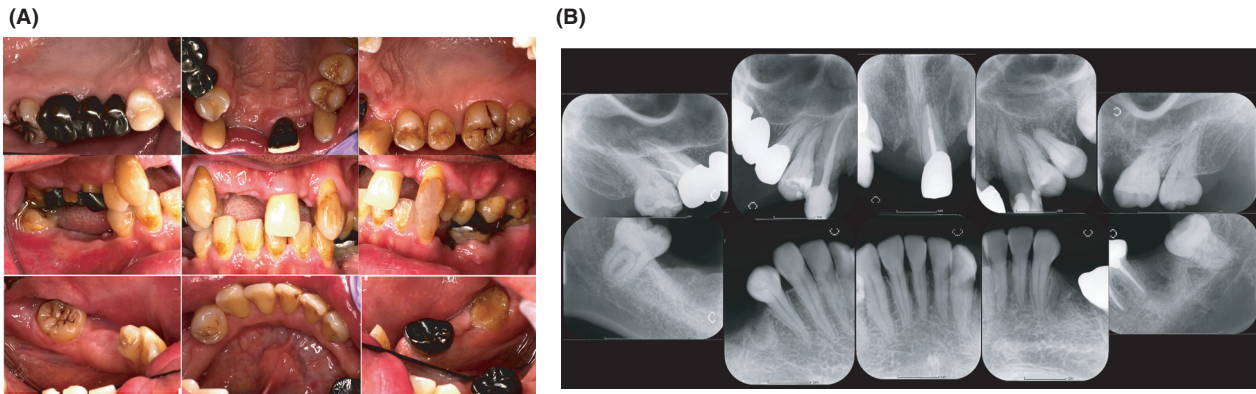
Intraoral view (A) and radiographs (B) before supportive periodontal therapy. (A) The gingival inflammation (redness and swelling) and tooth decay disappeared by removing the infection in the mouth. (B) The disappearance of radiolucencies around teeth at baseline by removing the infection in the mouth suggests the absence of infectious focus.
